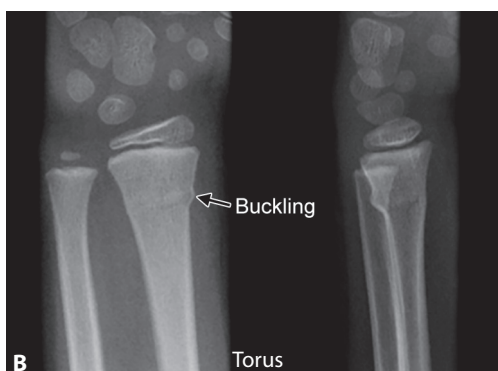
to F X-ray: Various fracture patterns
